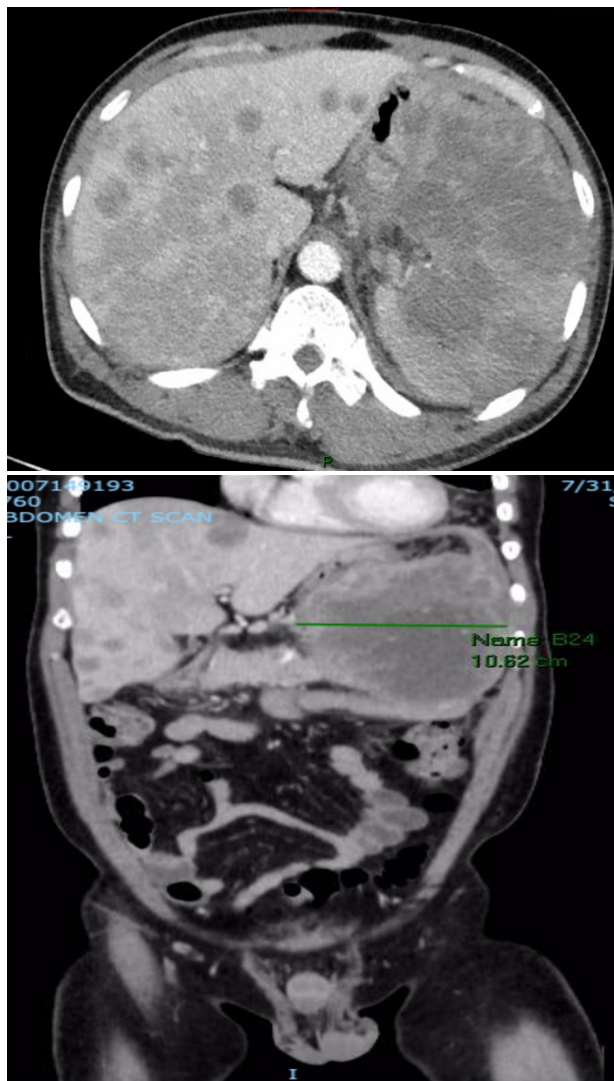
Abdominal CT. Arising from the greater curvature of the stomach was a large exophytic mass with necrotic components.
